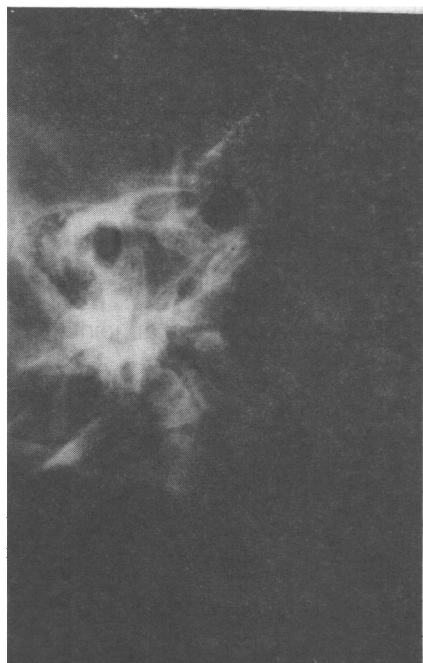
3 X-ray show displaced condylar neck with medial overlap
